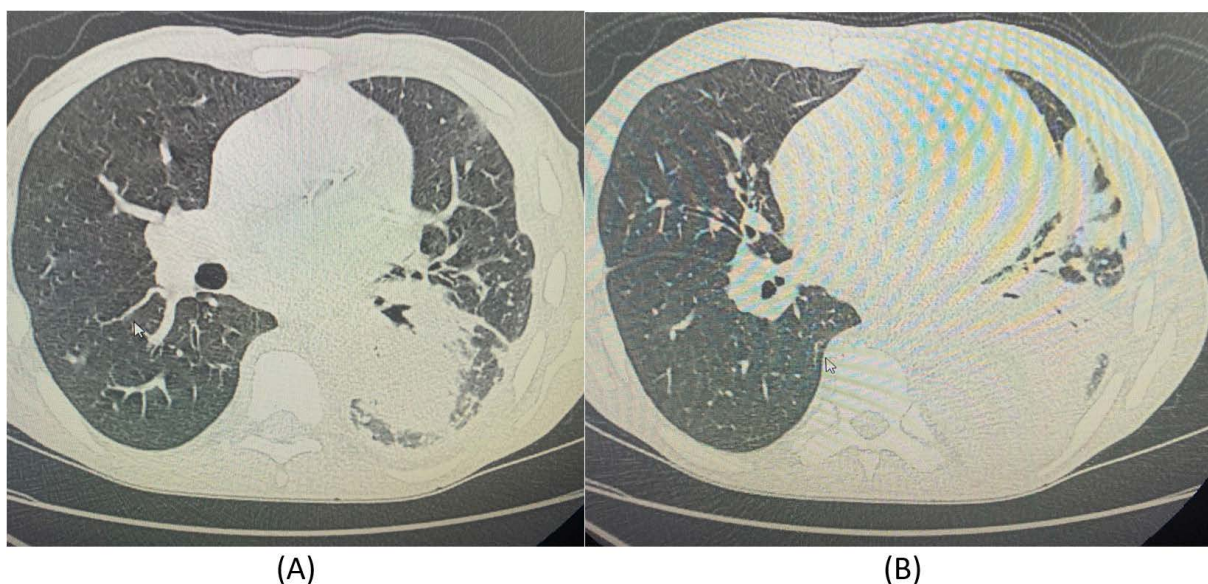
CT scan of the thorax showing the pleural collection on the left side
